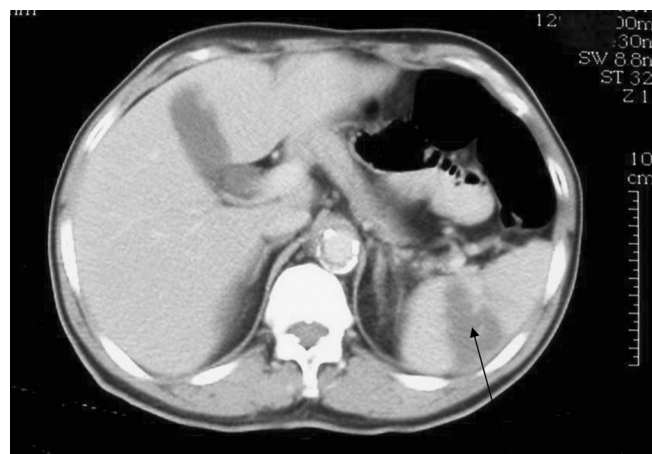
Axial post-contrast-enhanced CT image showing an elongated well-circumscribed hypodense area in the spleen (arrow) with normal enhancement of the remaining normal splenic tissue.
